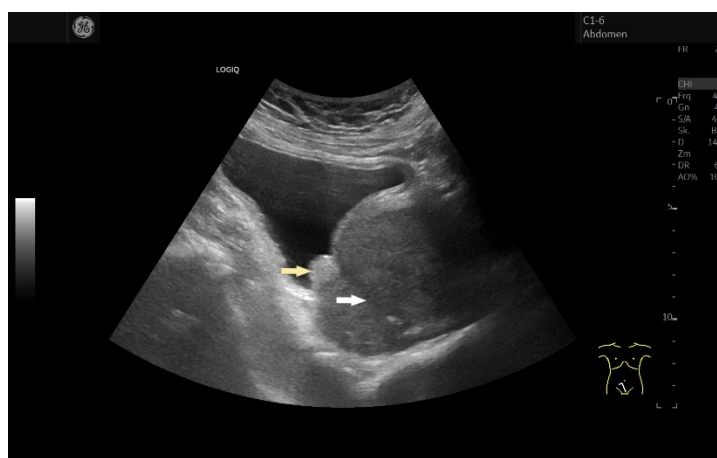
Hypoechoic enlarged and rounded prostate in cross-section with enlarged TZ. The PZ is narrow (a). In sagittal section it is visible that the urethra is displaced (white arrow). A hyperechoic nodule (yellow arrow) is visible at the base of the urinary bladder (b). This corresponded to a thickening of the trigone of the urinary bladder in transversal section (c) and in the MRI.
